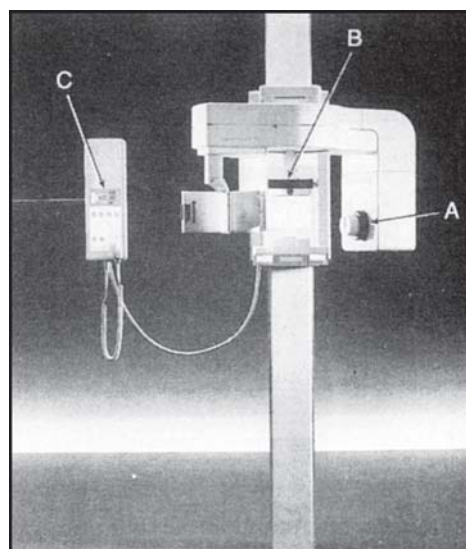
The main components of the panoramic unit include: A. The X-ray tube head. B. The head positioner. C. The exposure controls
